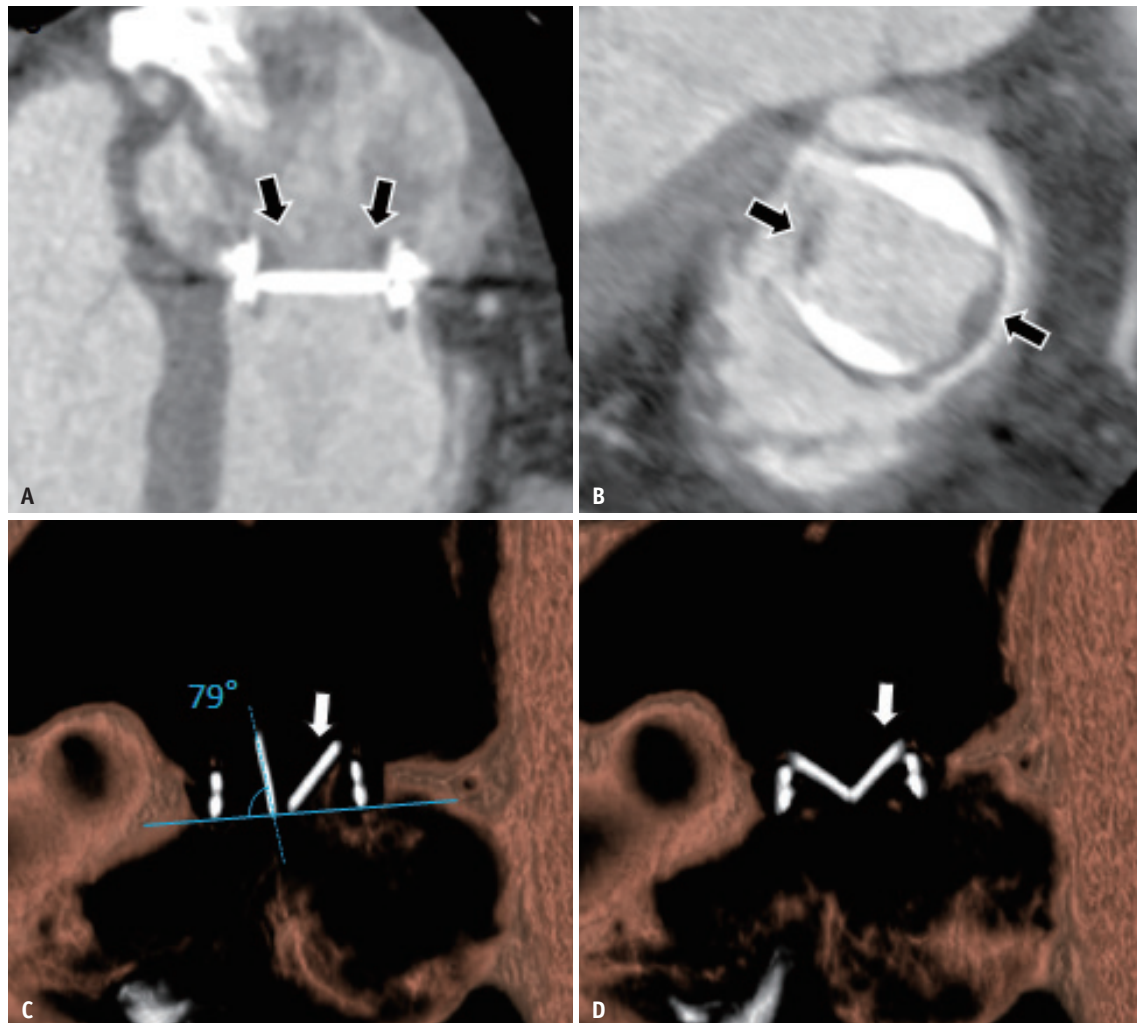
Mechanical valve thrombosis. A 35-year-old male underwent tricuspid valve replacement with an On-X 31/33 mm. A, B. On cardiac CT acquired 6 years after the operation, low attenuating soft tissues (40–60 Hounsfield units) can be seen attached along the inner lumen of the prosthetic mitral valve (black arrows). C, D. An immobile posterior leaflet (white arrows) is observable on the volume-rendered profile view images during diastolic and systolic phases. The motion of the anterior leaflet was normal, with an opening angle of 79° being within the normal range. Supplementary Video 1 also demonstrates the immobile posterior leaflet on volume-rendered multiphase cardiac CT images.
